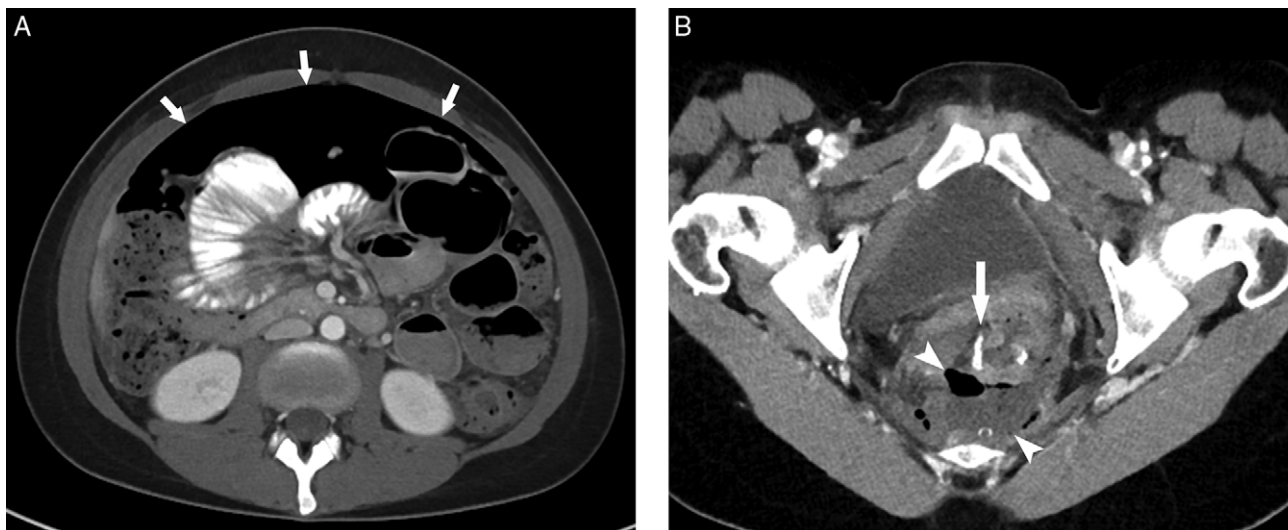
CT scan of the abdomen with i.v. and oral contrast from postoperative Day 5. (A) Large pneumoperitoneum found between bowel and abdominal wall (arrows). Gas- and fluid-filled loops of small bowel indicate ileus. (B) The radiopaque anastomotic staple line (arrow) and presacral extraluminal fluid and gas collection (arrowheads) are clearly shown.
